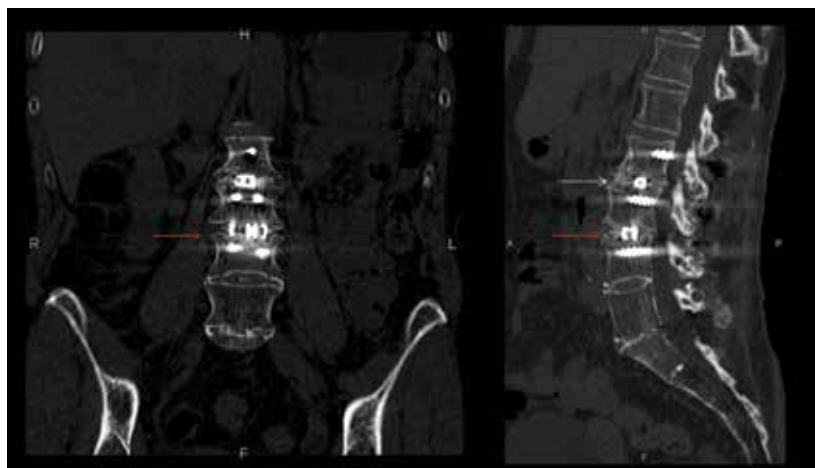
Thin-slice diagnostic CT with sharp kernel to define bony details shows irregular surface of the upper end plate of the L4 vertebrae (red arrows). The upper end plate of the L3 vertebrae also shows significant irregularities (white arrow). However, due to xSPECT Bone, the increased uptake in the upper end plate of the L4 vertebrae is clearly defined as the cause of the pain due to the osseous stress related to impression fracture and related instability. Although the upper end plate of the L3 vertebrae also shows irregularity, the degree of hypermetabolism is mild and suggests insignificant relevance to the pain. The artifacts due to metal in the pedicle screws and interbody cages hinder the true assessment of the bony abnormalities and disc space erosion. The CT also shows significant bone loss, loss of trabeculae, suggestive of osteoporosis, which may have been instrumental in the impression fracture of the L4 upper end plate.
